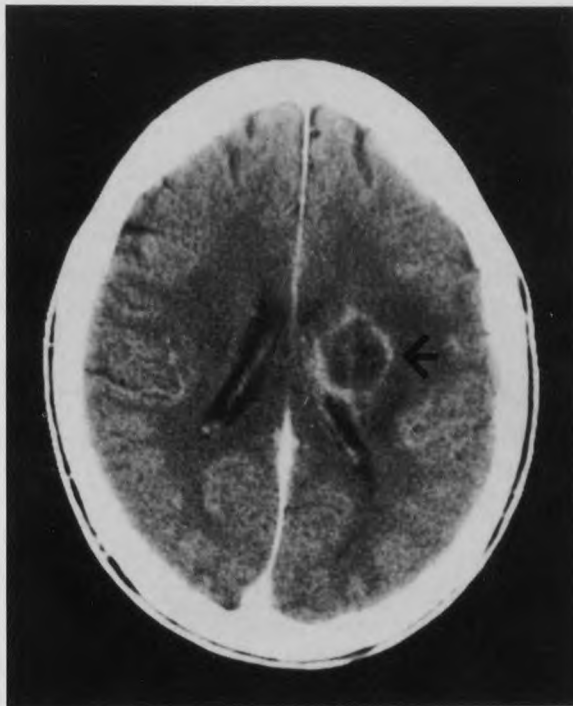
A head CT scan of a 33-year-old man with AIDS shows a single left-sided round lesion in the basal ganglia. An MRI of his head taken 10 days earlier, before treatment for cryptococcal meningitis, had been normal. He presented on the day the CT was performed with right-sided hemiplegia. He was empirically treated for toxoplasmosis with excellent results.
